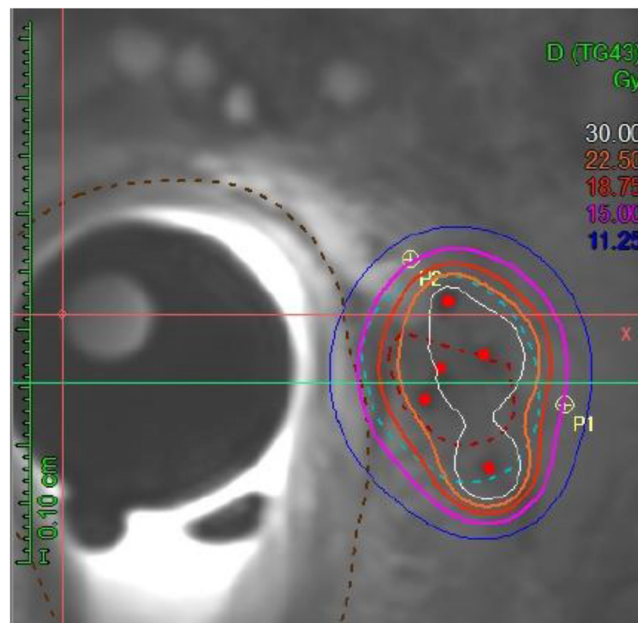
Pelvic magnetic resonance imaging (MRI) scan with dose distribution for the mesorectal nodule recurrence in prostate cancer (case 2).
